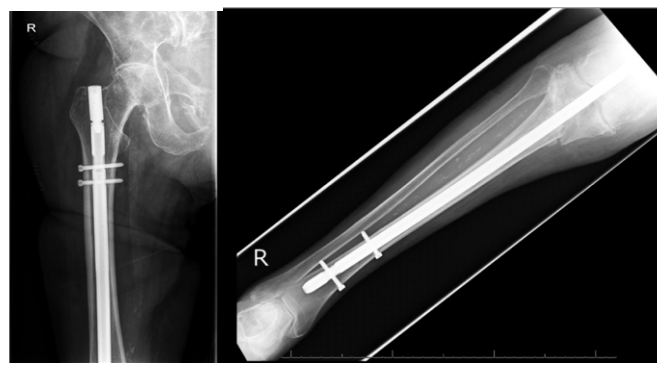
Immediate post-operative radiographs showing fixation of fracture with long femoral-tibial nail. (a) Anteroposterior (AP) view of proximal femur, (b) AP view of tibia.
